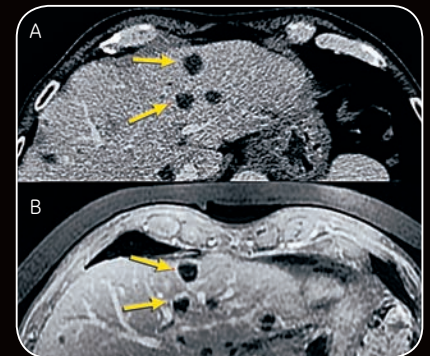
(A) CT follow up at portal phase; (B) 3D LAVA T1 (GRE) MR
